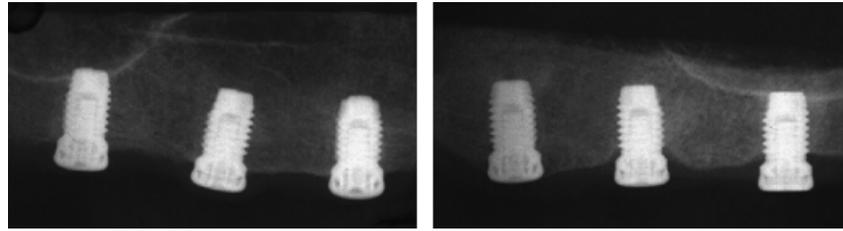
Radiographs from the left and right maxilla obtained at week 16 post-implantation. The titanium porous oxide surface implants in the right panel were coated with recombinant human bone morphogenetic protein-2 (rhBMP-2; 2.0 mg/ml). No appreciable differences may be noticed between jaw quadrants receiving rhBMP-2-coated or uncoated control implants. The distal implants appear to have penetrated the floor of the maxillary sinus.
